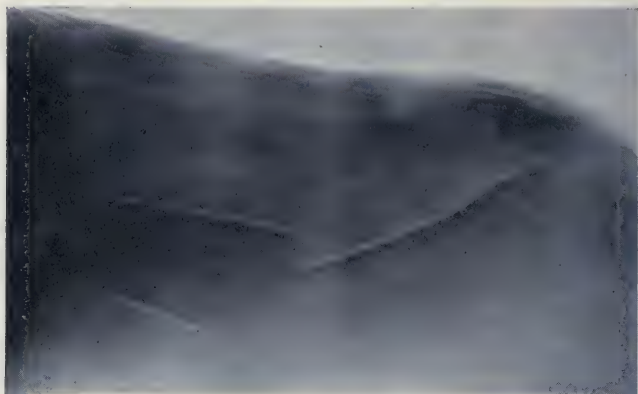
Anteroposterior x-ray of left femur before reduction (Case II).
